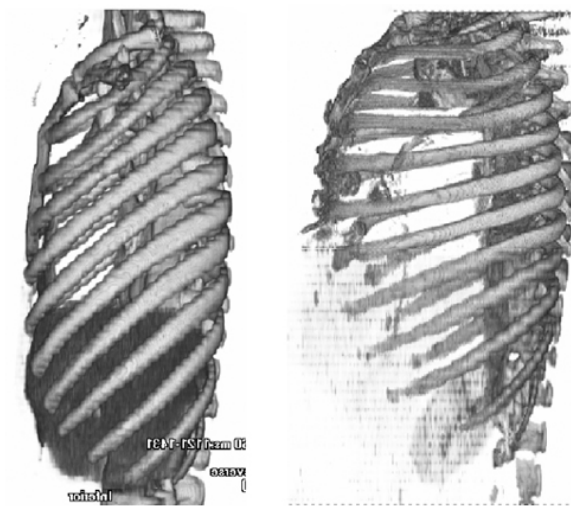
Three-dimensional CT reconstruction of the rib cage from two individuals shows a large difference in rib angulation.
